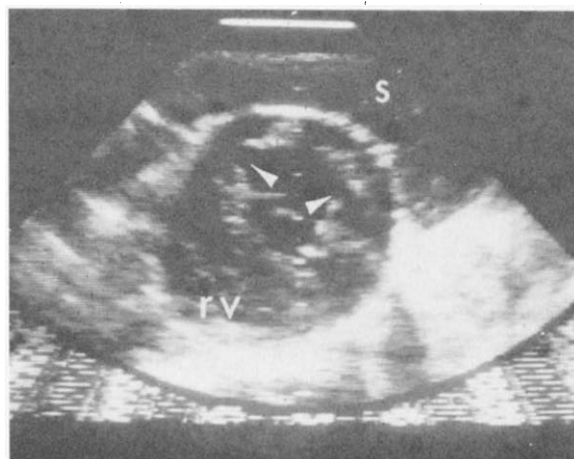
Two-dimensional echocardiogram in end-systole during coronary occlusion showing short-axis section at the level of the papillary muscles. The area which thins during systole is marked by arrowheads. Saline-filled glove (S) and right ventricle (rv) are indicated. Corresponding computer analysis of percent septal wall thinning for four consecutive cardiac cycles is shown below. Measurements begin at the midseptal point (0°). The central 45° of ischemia is marked between the first (F) and last (L) degrees of that octant, with the mean numerical value shown above.
